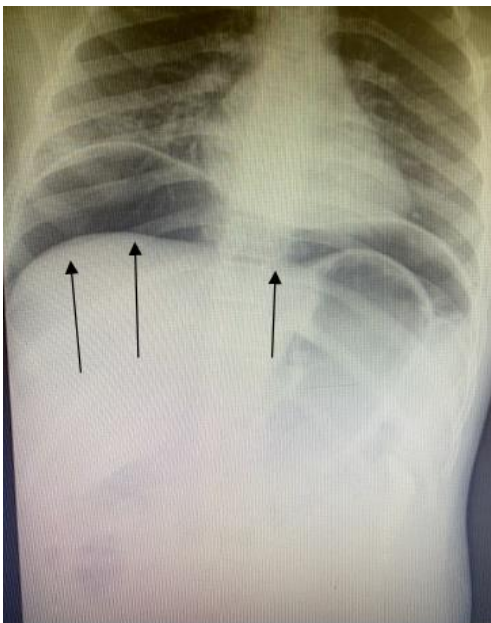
Post esophagogastroduodenoscopy X-ray shows free air under the diaphragm
